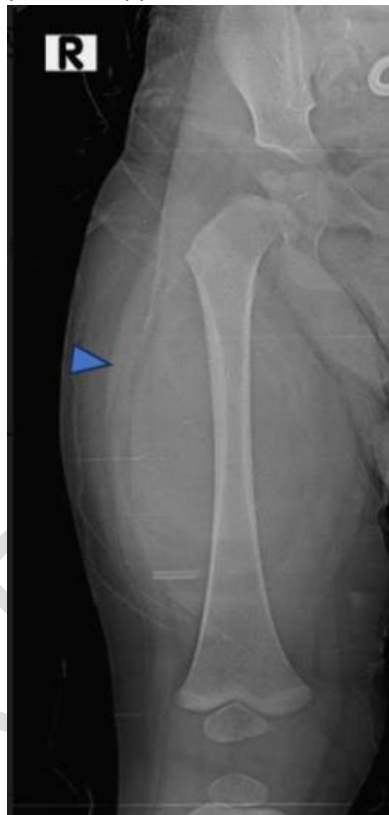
Femur X-ray showing a large oval opacity with clear and regular contours (blue arrow).
